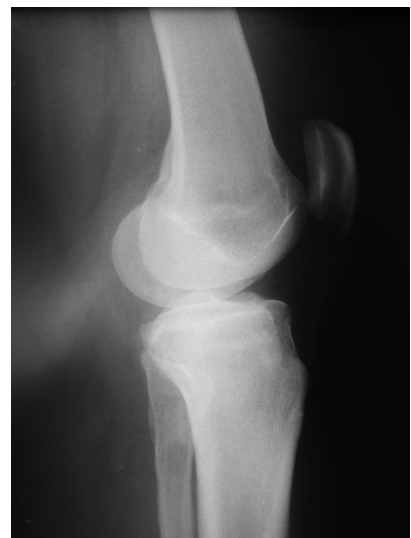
A postoperative follow-up x-ray demonstrating the full extirpation of the tumor
